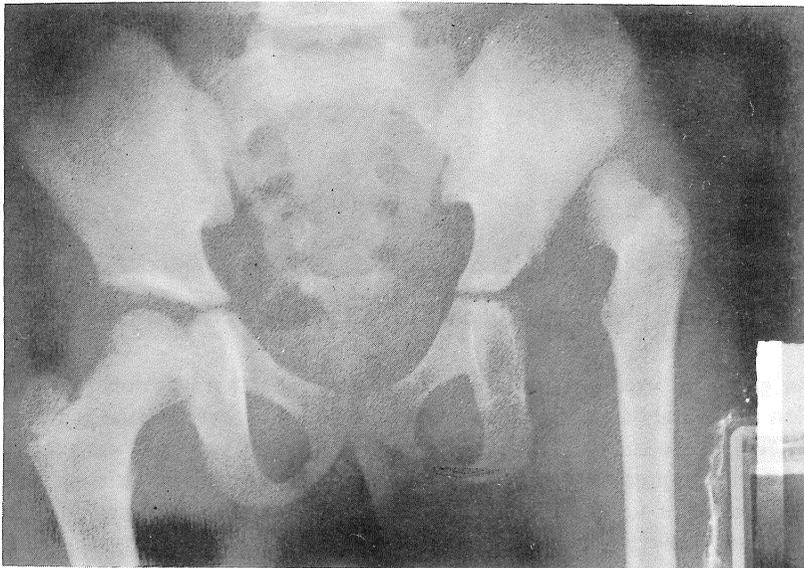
Pre-operative radiograph of a seven year old girl with left CDH.
